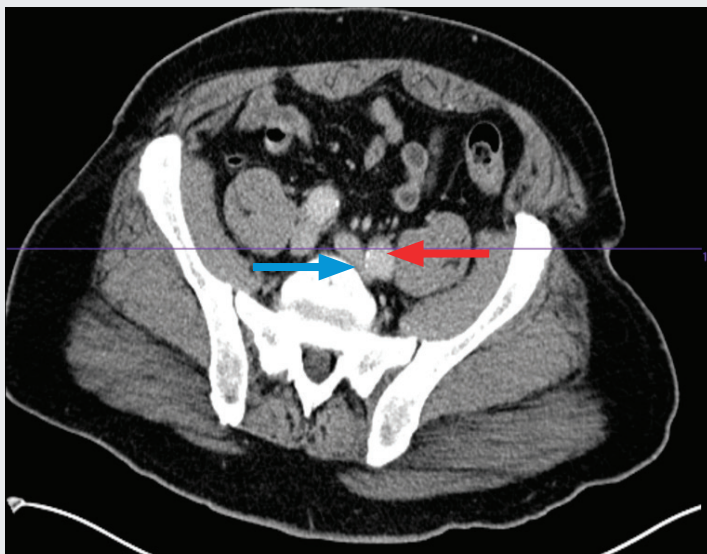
Enhanced axial CT of the abdomen and pelvis, demonstrating compression of the left common iliac vein (blue arrow) between the left internal iliac artery (red arrow) and the vertebral body at the S1 level.
